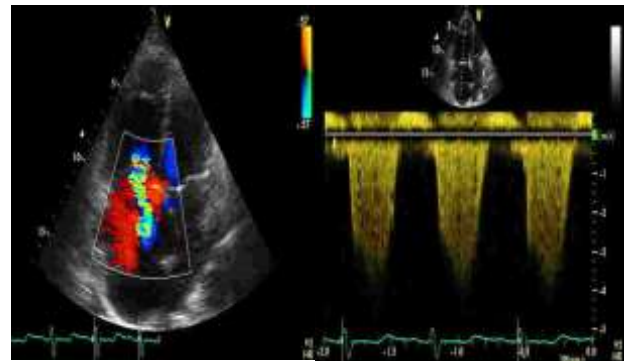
2D echocardiography with colour Doppler mode used in rendering tricuspid regurgitation jet maximization and measurement for tricuspid valve pressure gradient measurements via CWD techniques.
